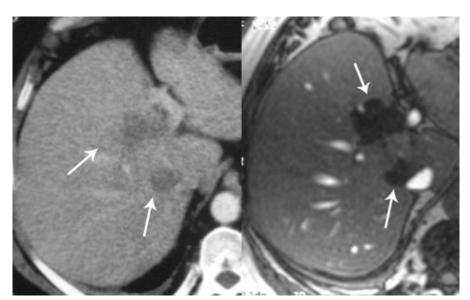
Two focal areas of low attenuation on CT liver CT in a patient with breast carcinoma. Out of phase sequence MR image proves them to represent focal fatty infiltration. Note the normal caliber of a vessel traversing the larger area of low signal.
